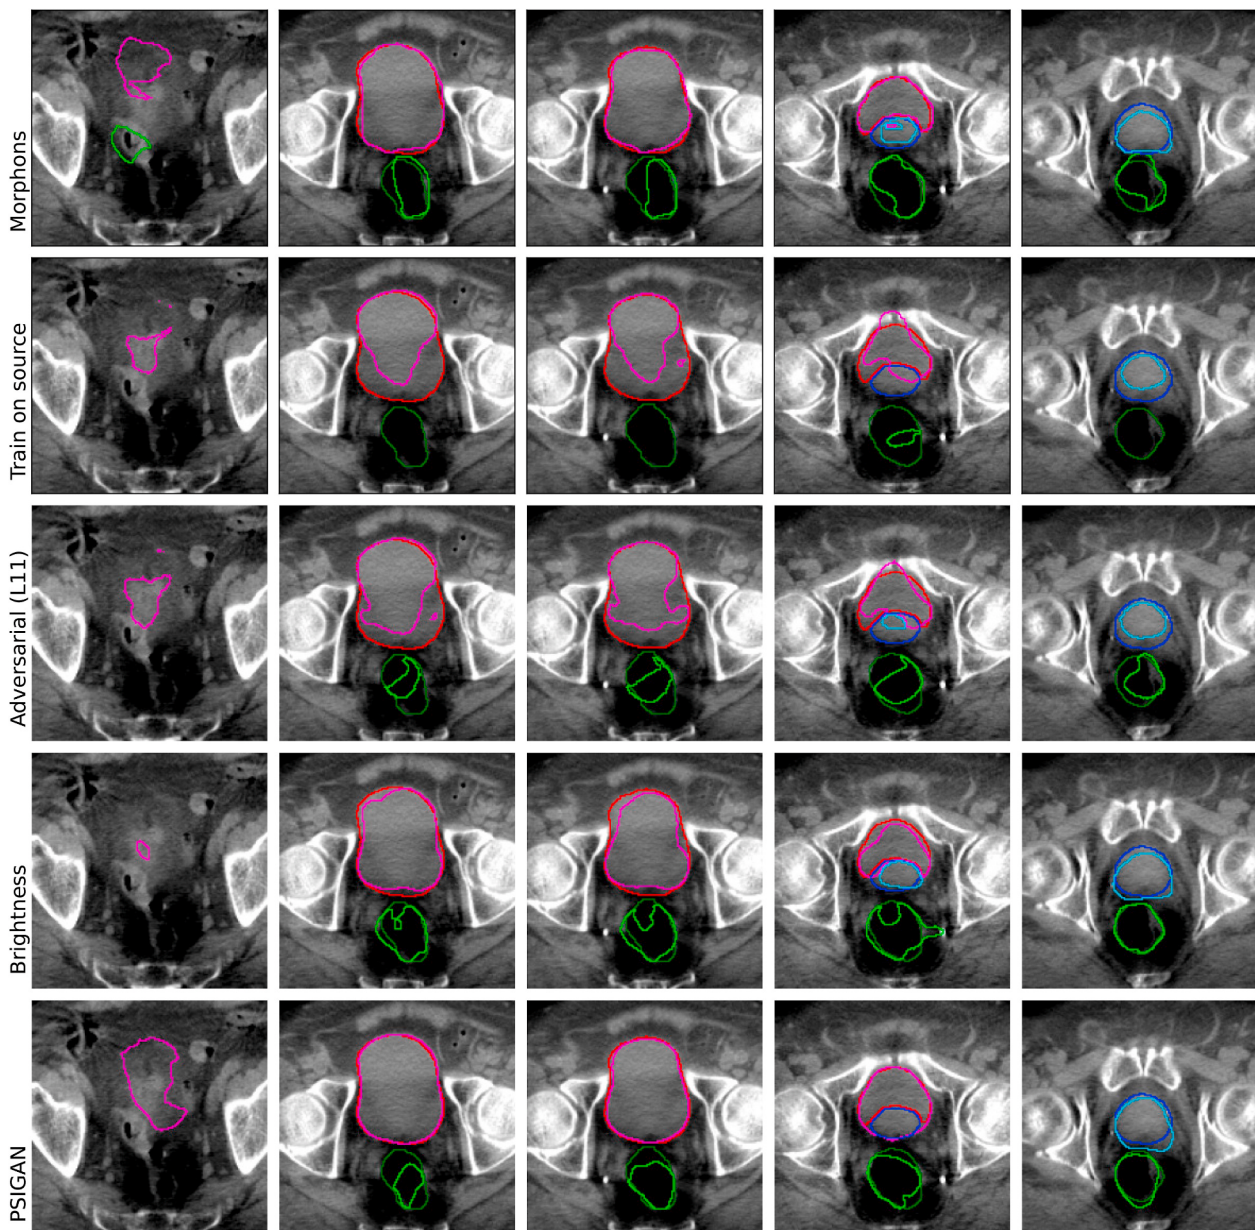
Comparison of morphons, “train on source”, adversarial networks with adaptation on L11, brightness, and PSIGAN segmentation for a representative patient from cohort $\mathcal{C}_4$. Each column corresponds to a slice of the same CBCT scan. Dark colors represent reference segmentations, while light colors show predictions from the different algorithms. Compared to “train on source”, Adversarial networks (L11) brings small improvements for the bladder (by detecting slightly larger portions of it) and the prostate (it is missed by “train on source” in the fourth column), as well as large improvement in rectum (since it is completely missed by “source on train” on most slices). Brightness performs similar to morphons for the prostate, slightly outperforms it for the bladder (fewer false negatives in the first column) and performs better for the rectum (no false negatives in the first column and more accurate delineation in the fifth). Color should be used for this figure in print.
